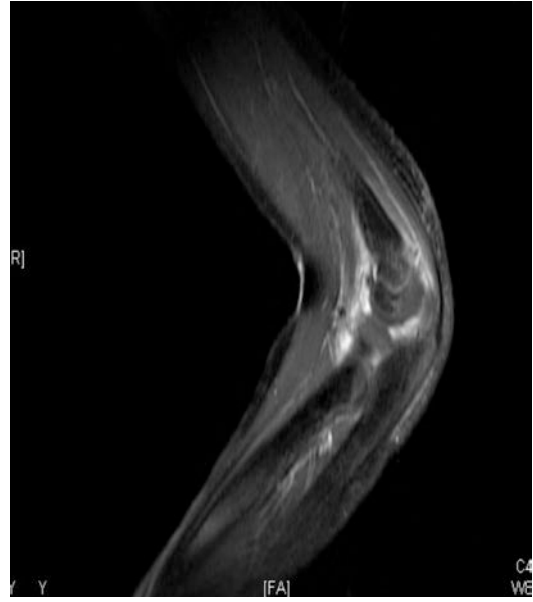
T1-weighted images on your right demonstrate no effusion
